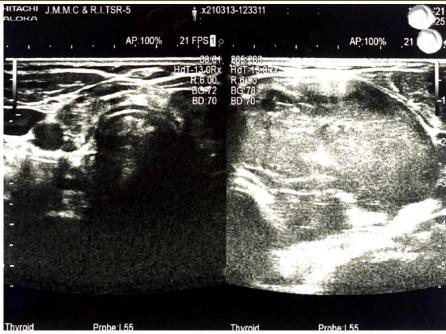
Ultrasonogram of neck showed features of resolving lymphocytic thyroiditis with multiple hypoechoic solid appearing nodules of 9 to 20 mm in left lobe (TIRADS 4)
